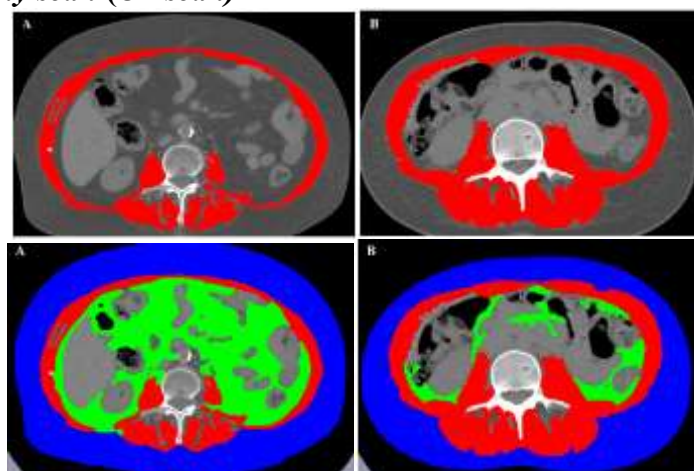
CT images of patients with sarcopenia (A) and non-sarcopenia (B). Skeletal muscle area (red) is reduced in patient A, which is especially visible in the paraspinal muscles, which appear larger and less infiltrated by intramuscular fat. Skeletal muscle index is measured using CSA and height (CSA / TB^2) in patient A 38 cm² /m² and B 58 cm² /m². Body composition on CT of sarcopenia (A) and non-sarcopenia (B) patients. Skeletal muscle area (red), visceral adipose tissue (green), and subcutaneous adipose tissue (blue) 3.(Chianca et al., 2021).
